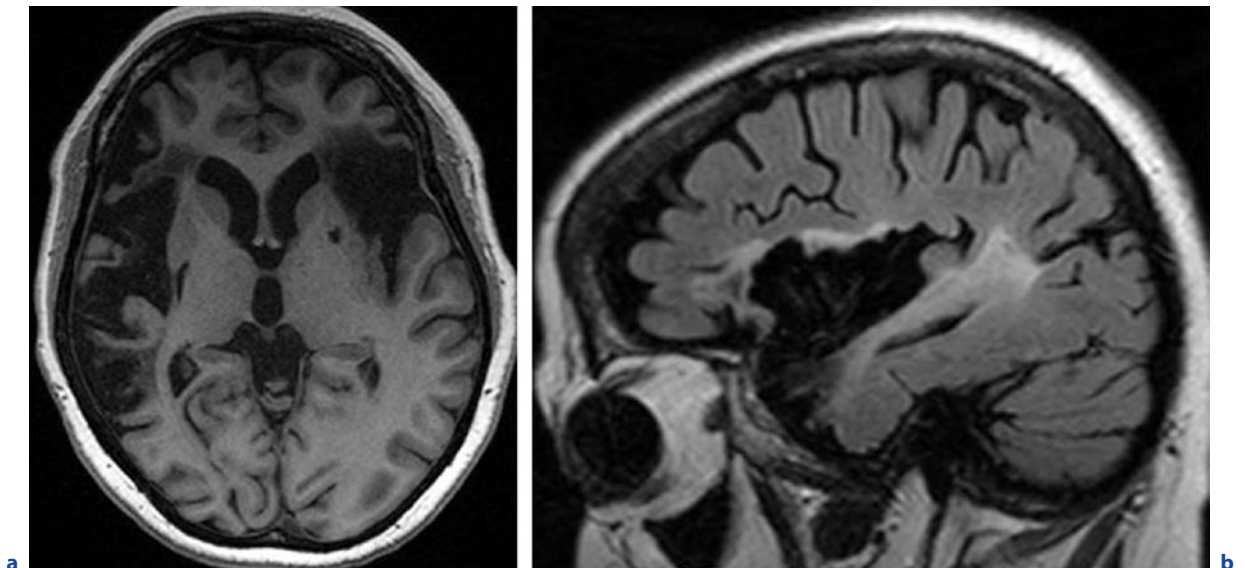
Systemic lupus erythematosus (SLE). This 46-year-old woman has been diagnosed with SLE 26 years ago and has been suffering from cerebral affection for 24 years. a Axial T1-weighted image. b Sagittal FLAIR image. Chronic
